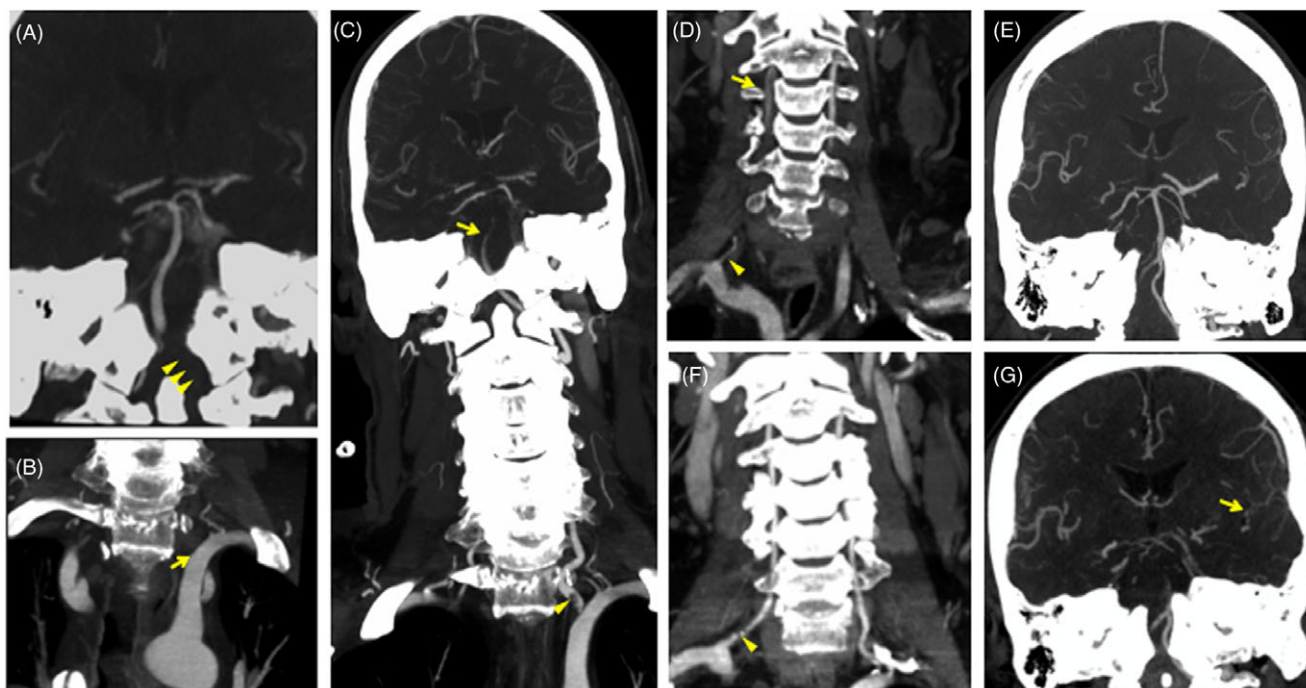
(A–C) are scans from patient 1 and (D–G) are scans from patient 2. *Patient 1:* Baseline CTA (A, B): (A) Lt intracranial VA was not seen (arrowhead). BA was patent. (B) Lt VA was occluded at the origin (arrow). Follow-up CTA (C) Lt VA was recanalized and thrombus at the origin of Lt VA was seen (arrowhead). BA was newly occluded due to thrombus migration from Lt VA (arrow). *Patient 2:* Baseline CTA (D, E): (D) Rt VA was occluded at the origin (arrowhead). The part of Rt extracranial VA was visualized and thrombus was seen in the VA (arrow). (E) The proximal portion of Rt intracranial VA was not seen. BA was patent. Follow-up CTA (F, G): (F) Rt extracranial VA was recanalized with severe stenosis (arrowhead). Thrombus seen on baseline CTA disappeared. (G) BA was newly occluded presumably due to thrombus migration (arrow).
